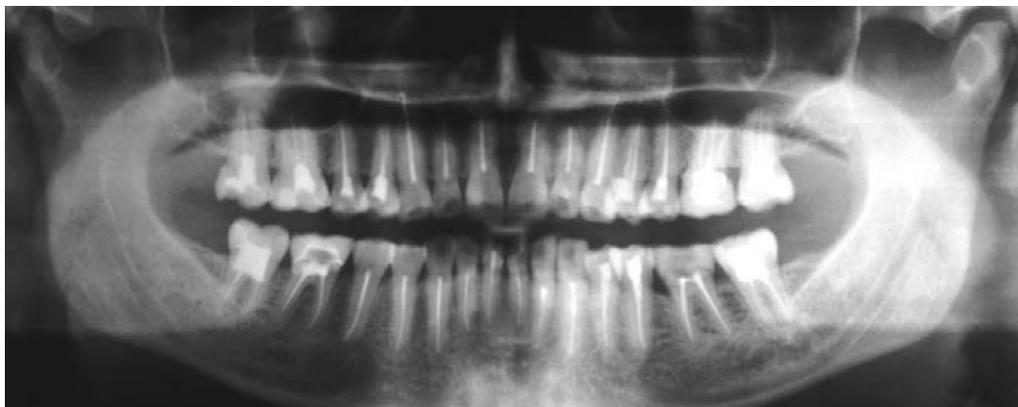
Radiograph of a TMD patient who perceived her TMD pain to be of pulpal origin and convinced dentists to treat her pain with endodontic therapy.
